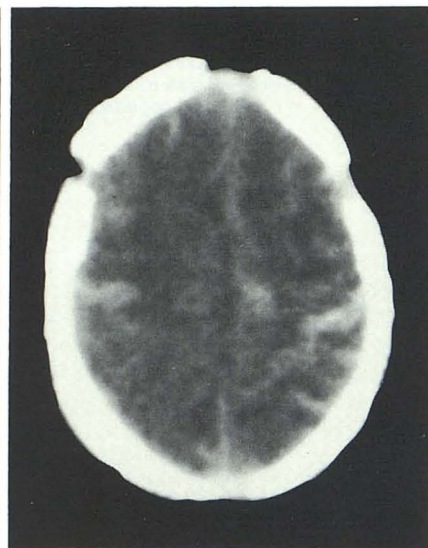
35-day-old infant. Unenhanced CT scans at 13 days after presentation. Very intense gyral fingerlike densities, mainly on right.
